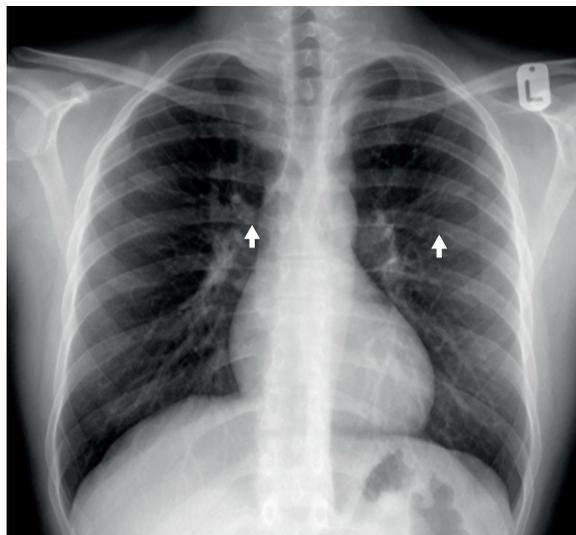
Chest radiograph of a patient with long-standing coarctation of the aorta demonstrating typical findings of coarctation: rib notching (arrows) and '3 sign' beneath the aortic notch.
